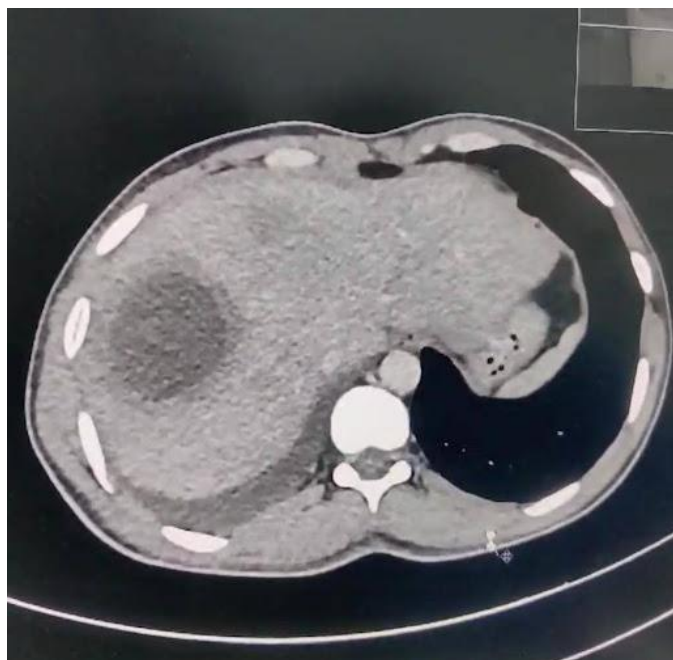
Computed tomography of the abdomen
